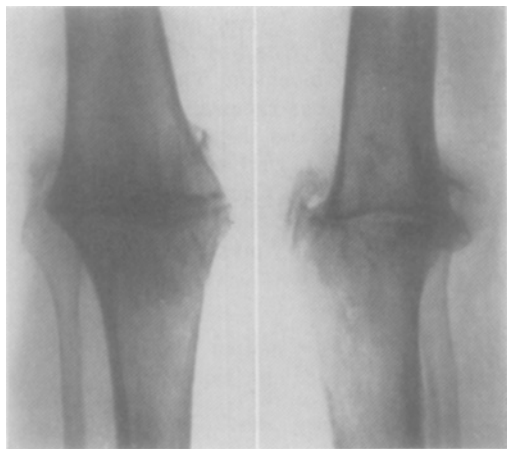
Case 13: roentgenograms of right knee; ankylosis after arthrodesis.
